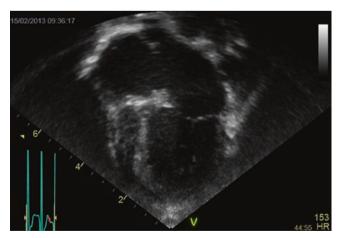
Echocardiographic image: tricuspid atresia, hypoplastic RV, apical four chambers view
